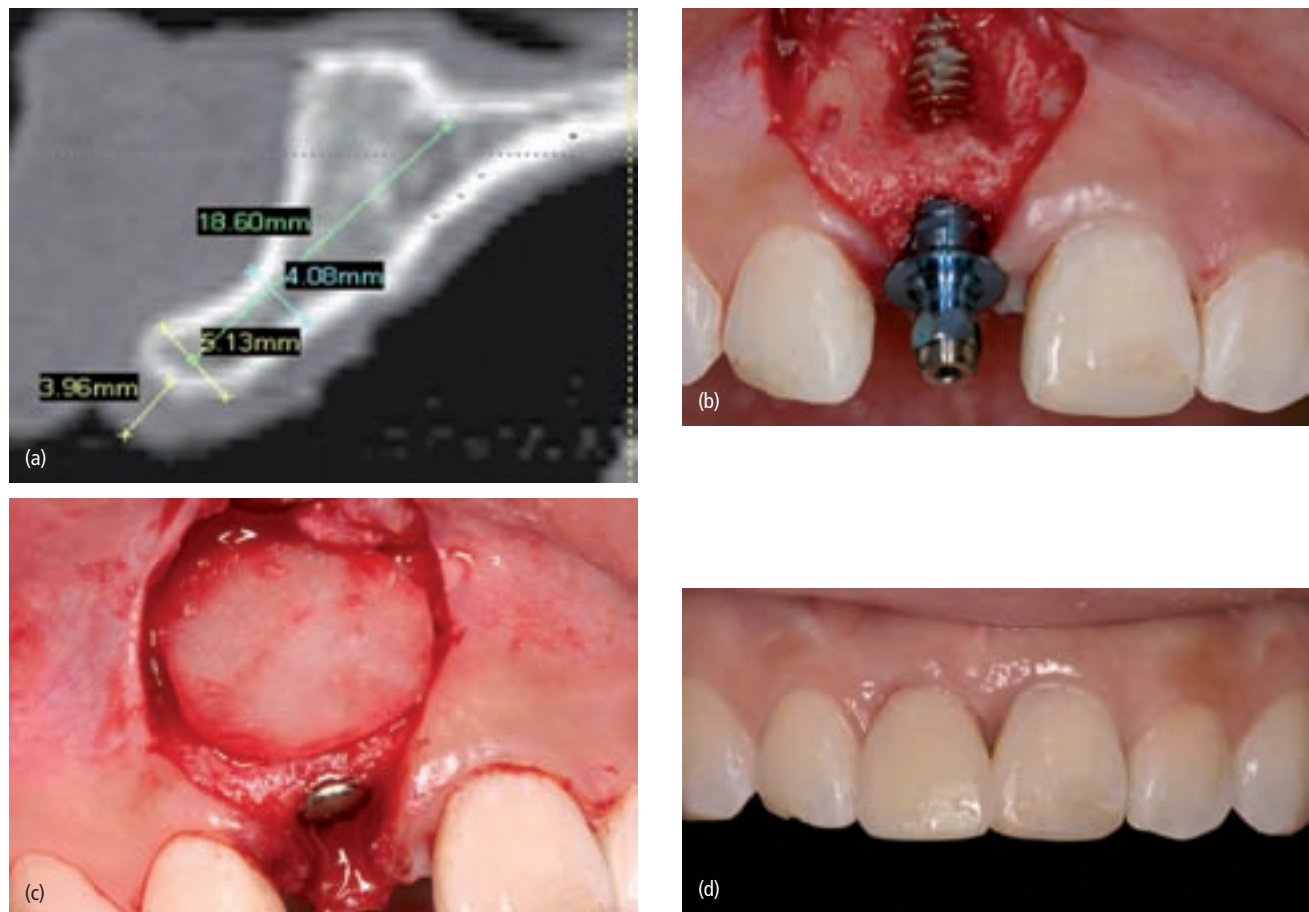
Treatment planning a problematic case at site 8. (a) CT scan demonstrating lack of buccal bone. (b) Implant placement creating expected buccal fenestration of bone. (c) Barrier positioned over the bone graft. (d) Restoration in place 5 months after implantation. (Courtesy of Dr Tai.)
